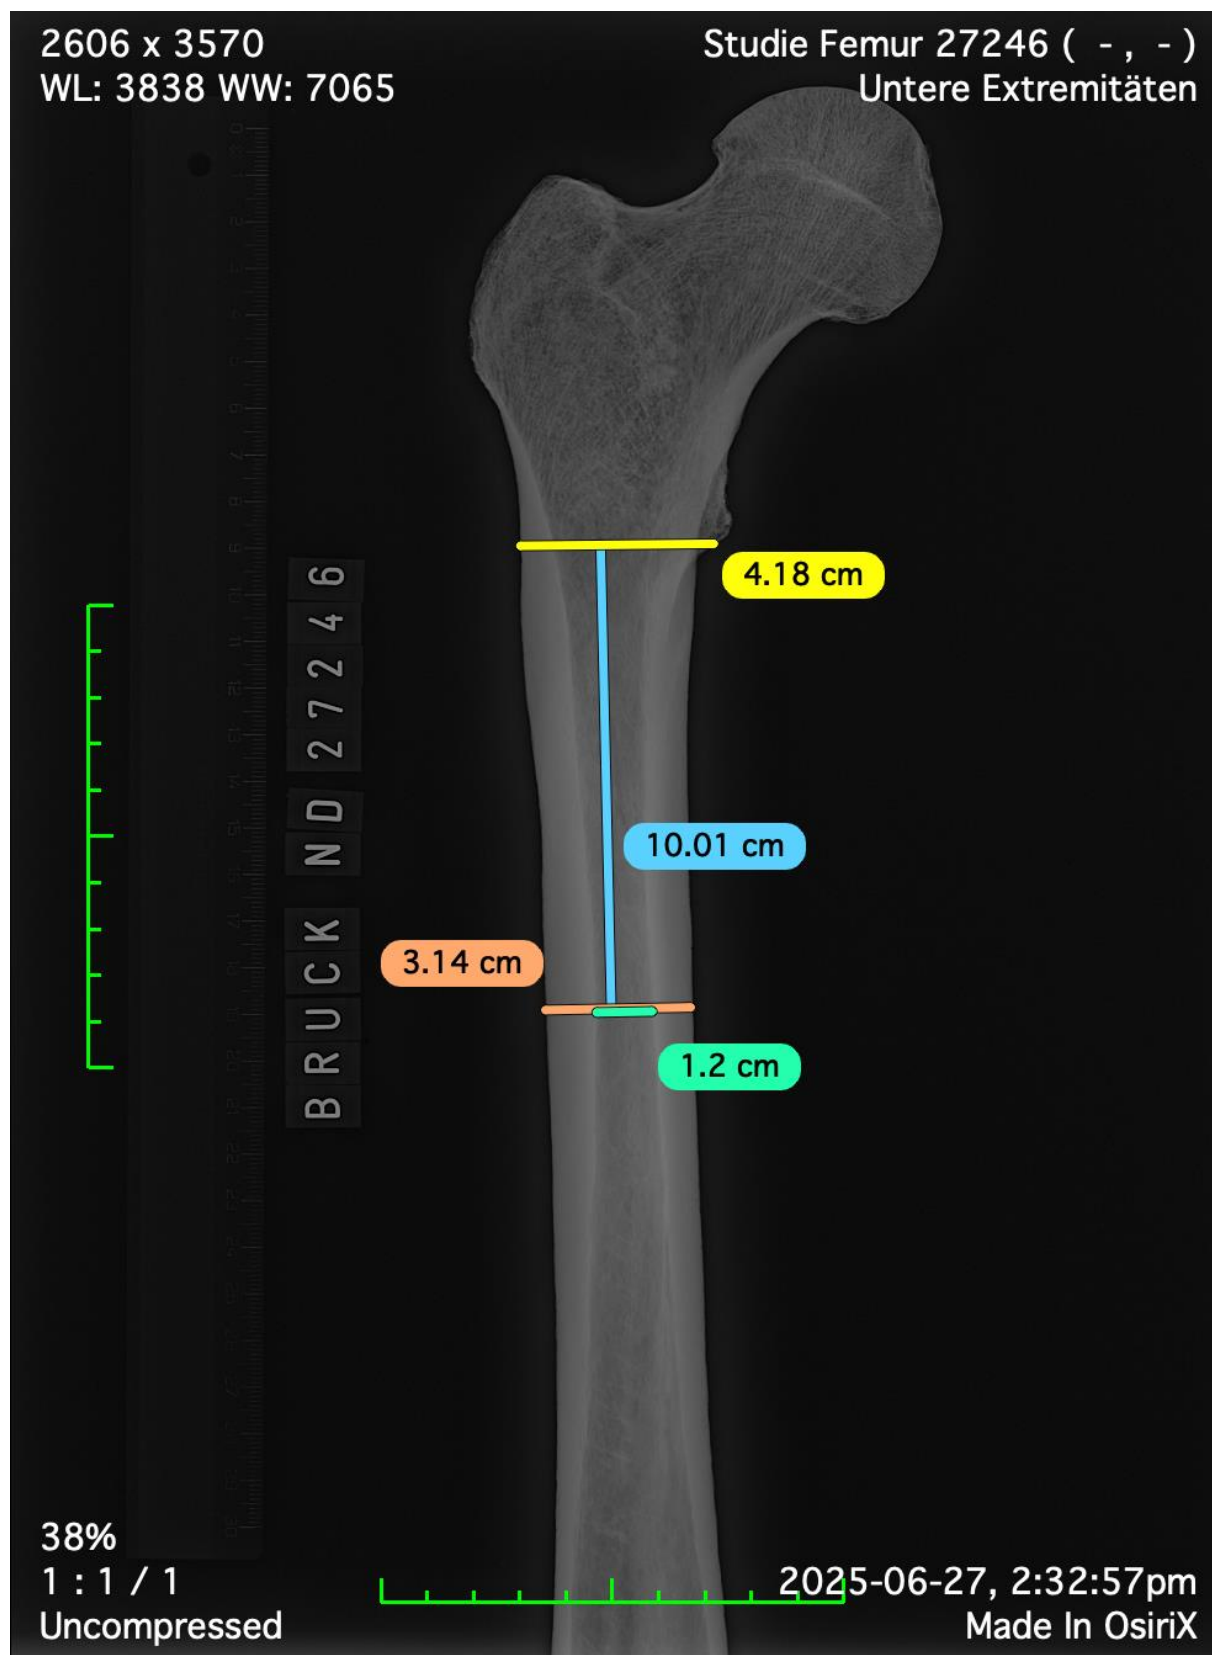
Example of femoral radiographic measurement for CTI in OsiriX (NHMW-Anthro-Oste-27.246). The yellow line marks the proximal reference level at the inferior margin of the lesser trochanter, the blue line marks the 10 cm distal location used for shaft measurement, the orange line marks total mediolateral shaft diameter, and the green line marks medullary cavity diameter.
